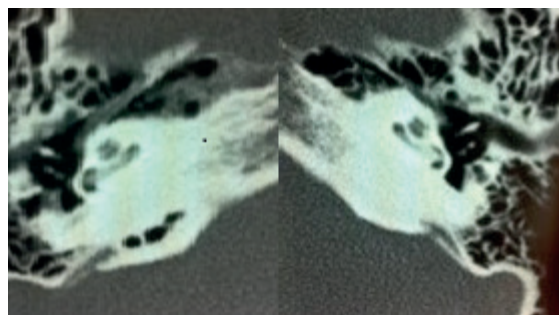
The CT image shows a partial obstruction of the basal turn of cochlea.
